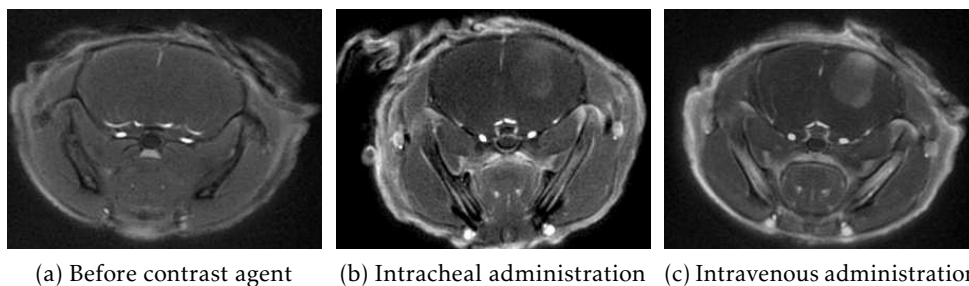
UTE MR images (a) before and after the (b) intratracheal administration of 50 μ L 200mM USRPs or (c) intravenous injection of 200 μ L 50mM USRPs.
